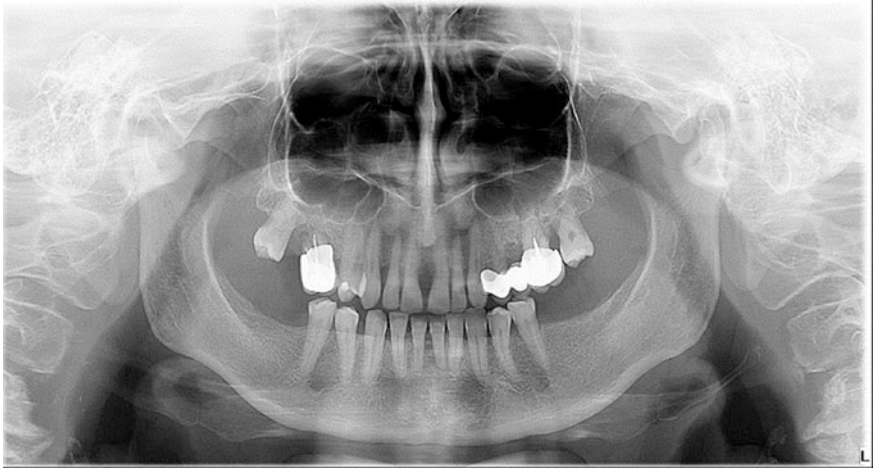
Orthopantomography: radiograph signs of severe periodontitis; restorations in tooth 1.5, 2.4, 2.5, 2.6
